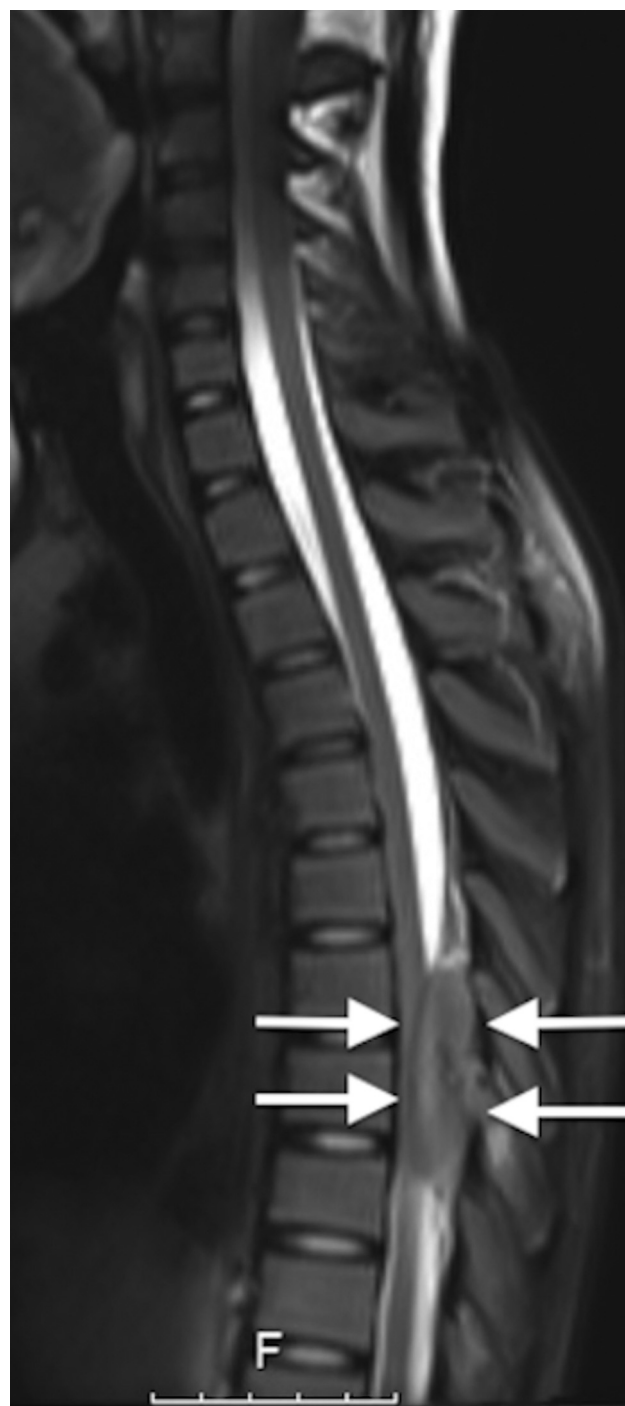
Sagittal T2-weighted magnetic resonance (MR) image, revealing hyperintense mass lesion with cord compression (arrows).
